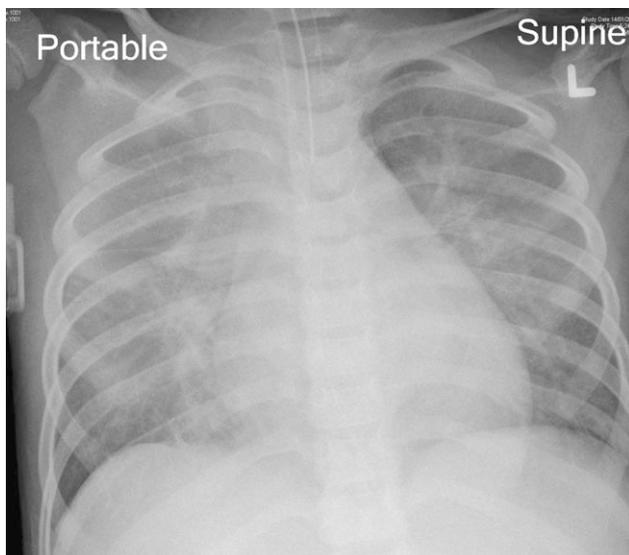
Interstitial infiltrates on chest radiographies.
